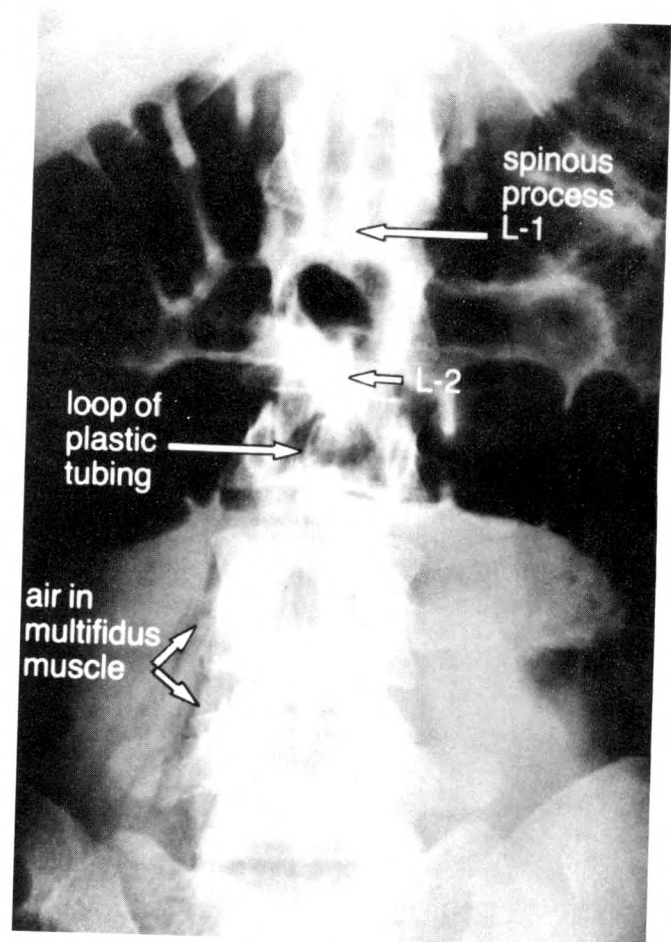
Anteroposterior roentgenogram showing sheared off radiopaque catheter at the L2-3 interspace and air in multifidus muscle.
